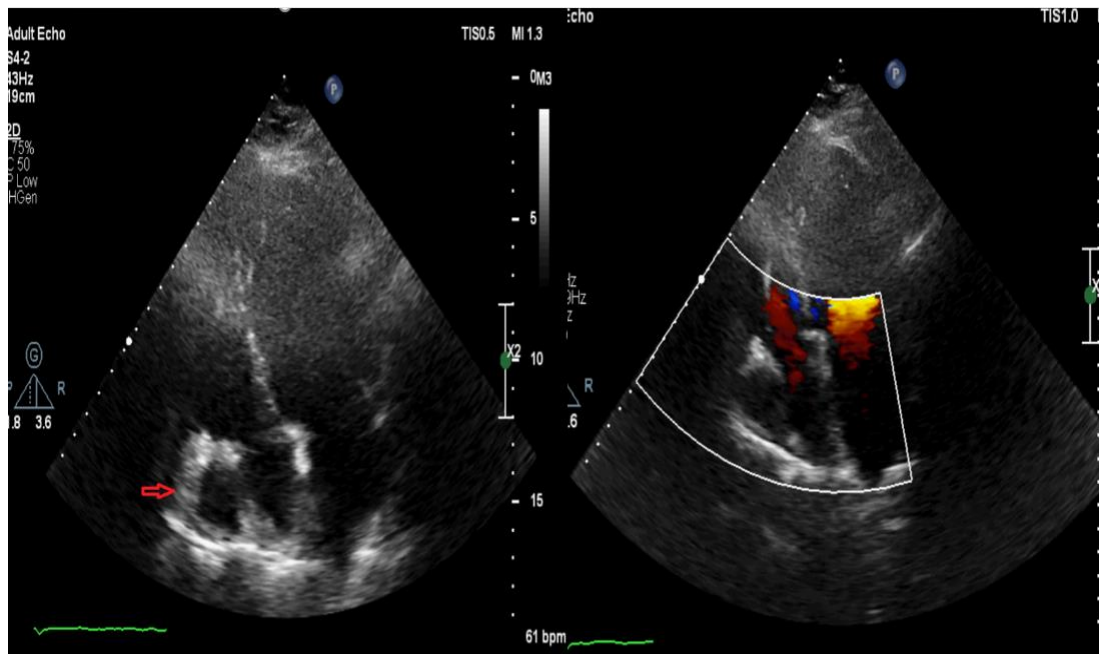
Transthoracic echocardiography (the 4-chamber view) reveals a cystic lesion lateral and inferior to the right atrium (the left image; the red arrow) with no color (the right image).
